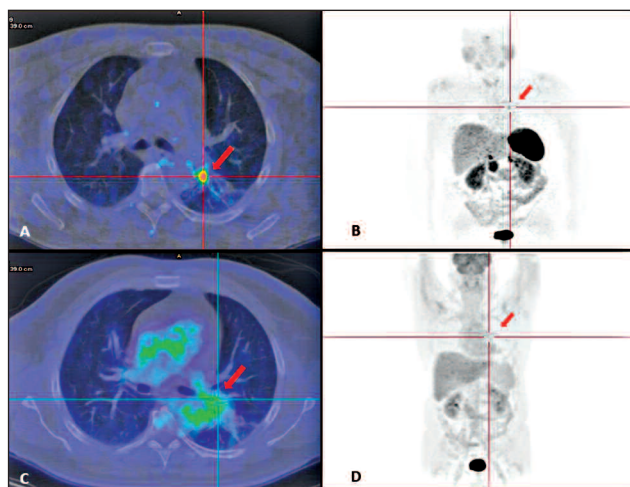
Metabolic pattern for TC, in CT (A and C) and in PET scans (B and D). Increased uptake of radiolabeled somatostatin analogues (A-B) and low or absent uptake of ¹⁸F-FDG (C-D). (Images from IRCCS, Arcispedale, Santa Maria, Nuova, Reggio, Emilia, Italy)
